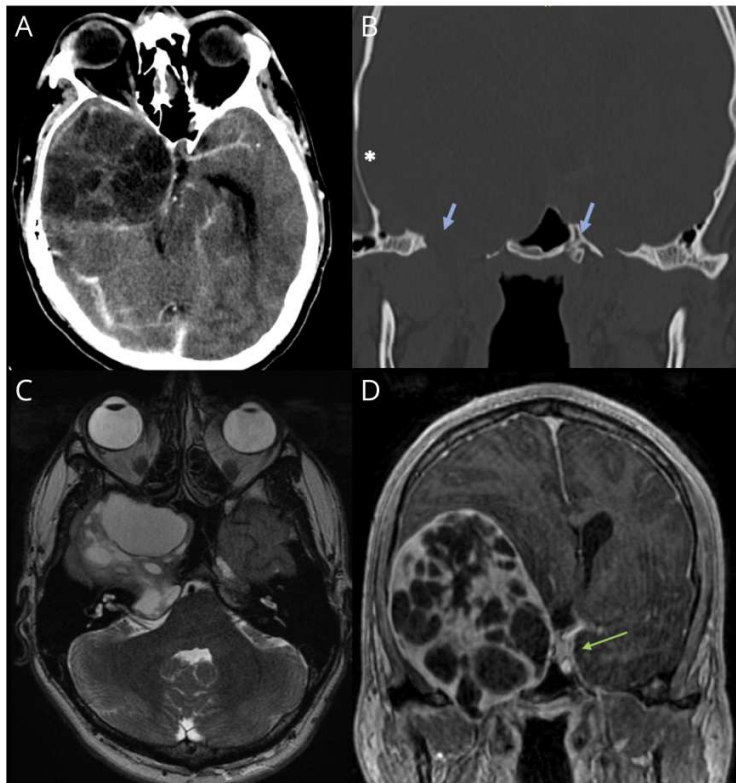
CT and MRI imaging showing a large cystic tumor
